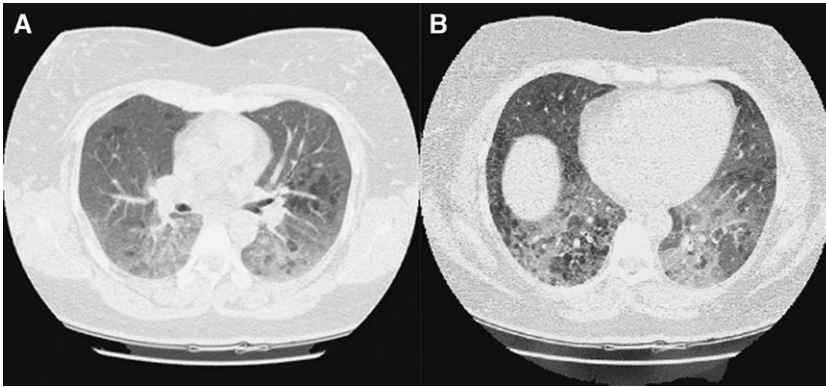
Acute HP. HRCT images (inspiratory and expiratory) show ground-glass opacity (*A*) with interspersed low-attenuation regions indicating air-trapping (*B*).
